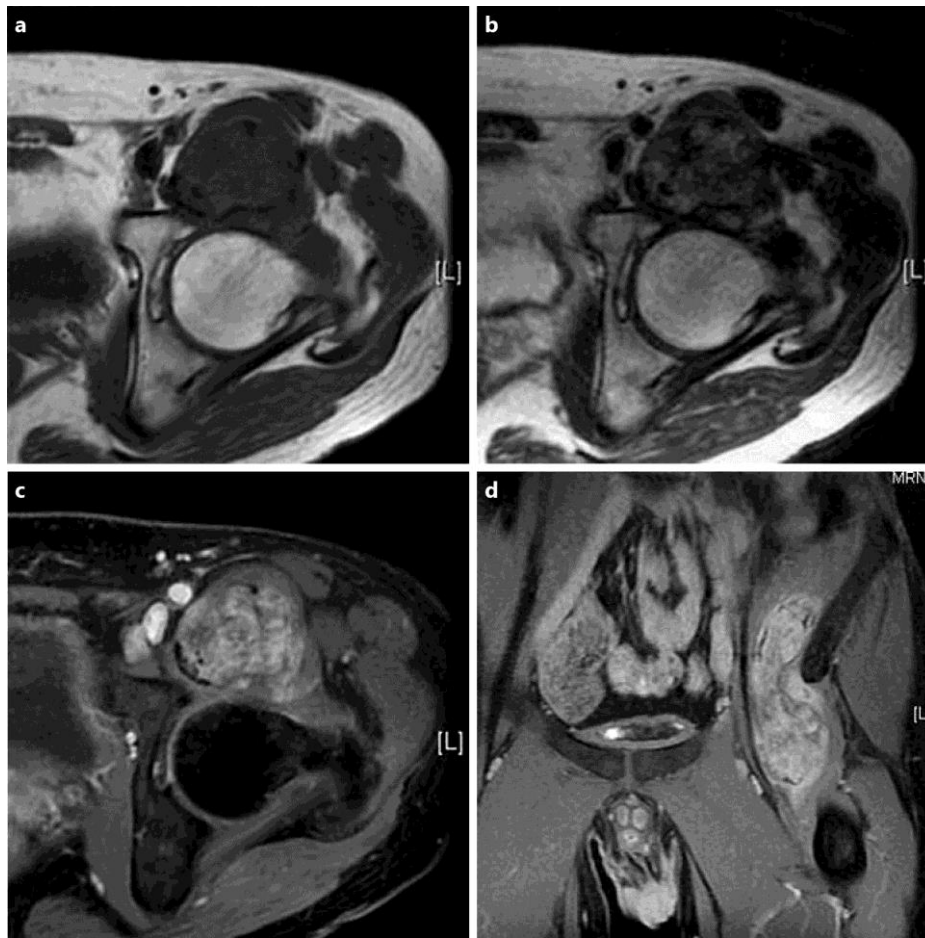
MRI showed a tumor extended from the medial aspect of the wing of the left ilium along the iliopsoas muscle to its site of insertion on the femur. The tumor was isointense on T1-weighted images (a) and heterogeneous hyperintense on T2-weighted images (b), and it was gadolinium enhanced (c, d).
